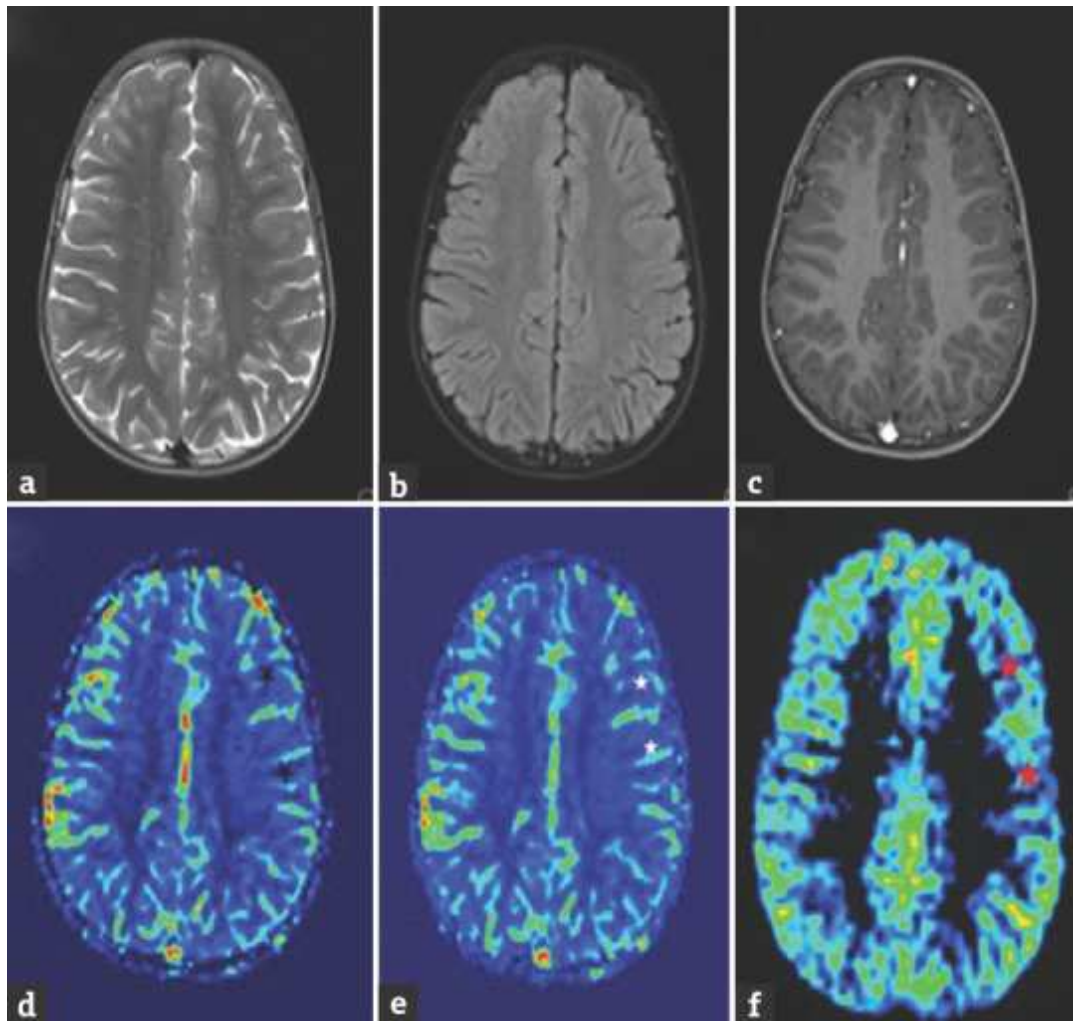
Magnetic resonance imaging of 11-year-old male child obtained 13 h after seizure onset showing no abnormality on axial T2 (a), fluid inversion recovery (b), postcontrast – T1 (c) while revealing hypoperfusion in left frontoparietal lobe on dynamic susceptibility contrast – cerebral blood volume ([d] black asterisk), dynamic susceptibility contrast – cerebral blood flow ([e] white asterisk) and arterial spin labeling ([f] red asterisk)⁶⁰
